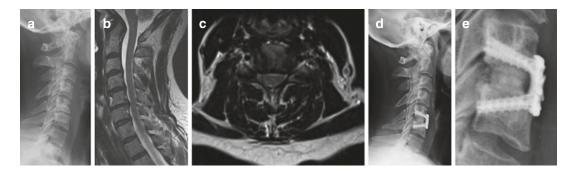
Plain neutral lateral radiograph (a) demonstrating disc collapse at C5/C6, osteophyte formation, and loss of lordosis. T2-weighted sagittal (b) and axial (c) magnetic resonance imaging (MRI) of the cervical spine demonstrating severe cervical stenosis at C5/C6 and right greater than left foraminal narrowing. Postoperative lateral neutral
